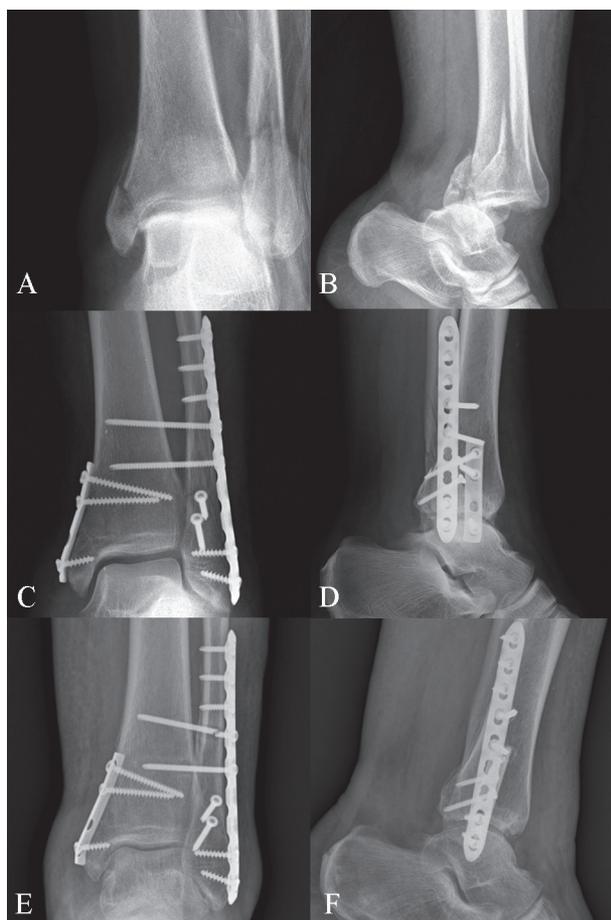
Preoperative x-ray of left ankle fracture (A and B); postoperative views (C and D); radiographs 4 months after surgery with syndesmotomic screw rupture (E and F)
